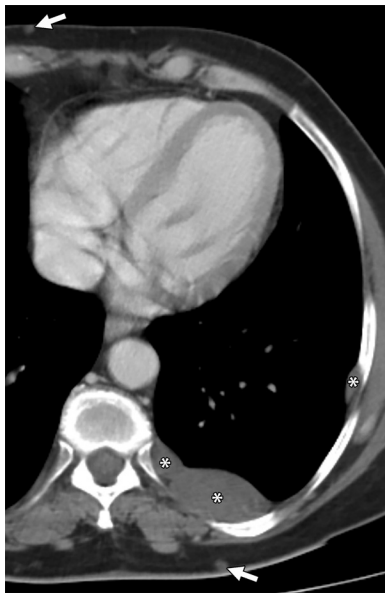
Neurofibromatosis type 1 and neurofibromas in the EPS. Axial cropped CT image shows multiple extrapleural (*) and subcutaneous (arrows) neurofibromas.
